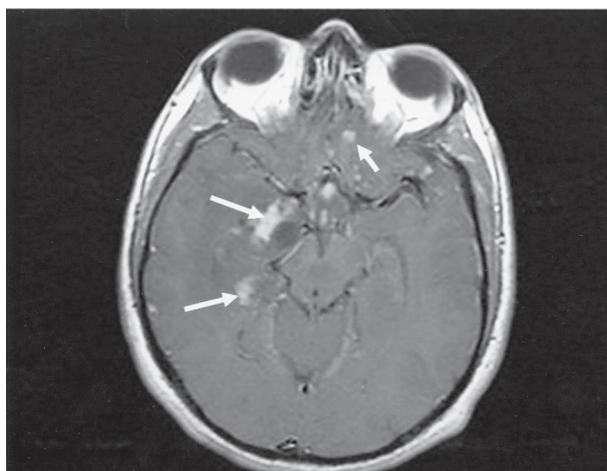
MRI brain, gadolinium- enhanced T1 weighted axial image confirmed the CT findings with more nodules seen at the right temporal and left frontal lobes
